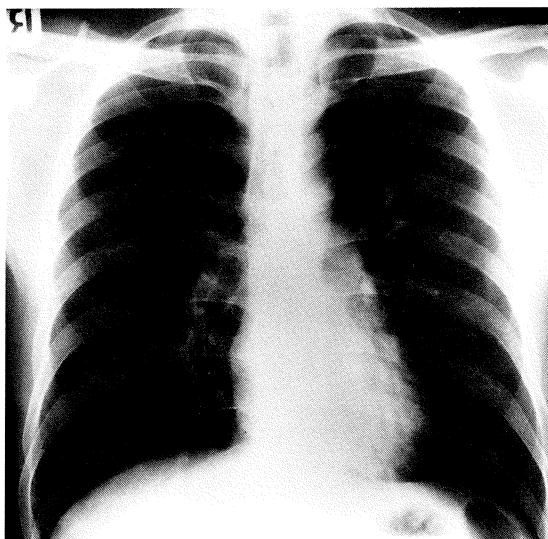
Follow-up chest radiograph shows complete resolution of the *Nocardia* pneumonia
